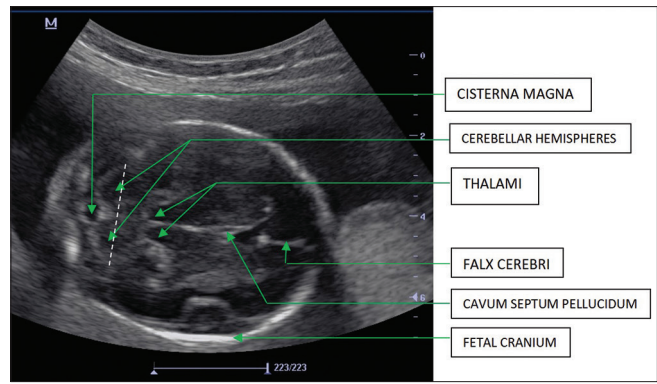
B-Mode transaxial sonographic appearance of Grade Ib cerebellum at 22 weeks GA showing rounded cerebellar hemispheres with poorly developed vermis giving the “eye-glass” appearance. GA: Gestational age
